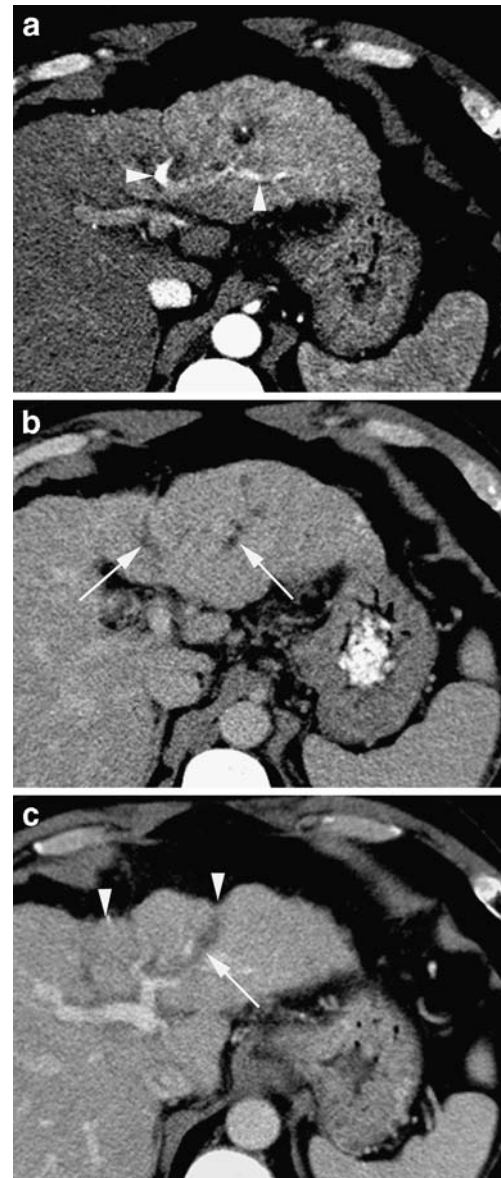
A 45-year-old man underwent two separate sessions of selective TACEs for treatment of multifocal hepatocellular carcinoma showing portal tract injuries consisted of arterioportal fistula formation and portal venous narrowing in the left lobe of the liver. a Ill-defined THAD (arrowheads) in lateral segment of left lobe of the liver is associated with early appearance of subsegmental portal vein enhancements (arrowheads) on the arterial phase dynamic CT. b Equilibrium phase of contrast-enhanced CT shows normalized attenuation density of the previously enhancing segment. Linear low-attenuation densities suggests portal tract injuries (arrows) with alongside venous compromise. c Portal phase dynamic CT taken 5 months after TACE reveals that the considerable parenchymal atrophy (arrowheads). Subsegmental portal vein obliteration (arrow) is also demonstrated
